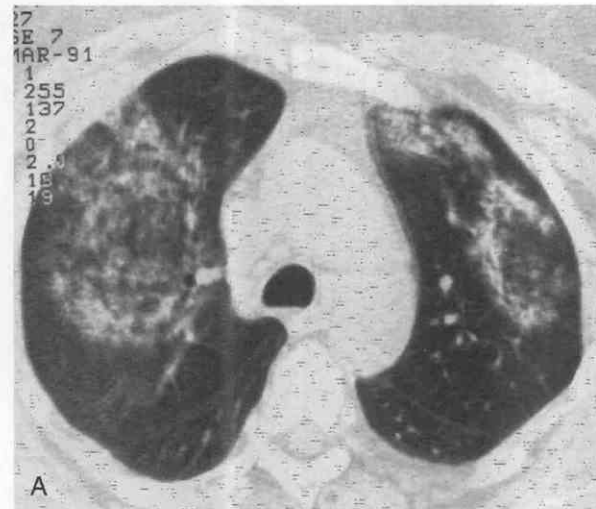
This patient presented with hemoptysis caused by Wegener's vasculitis affecting primarily the capillaries of the lung. A and B, On CT scans, patchy air space filling is seen as a result of pulmonary hemorrhage. C, A few weeks later, a CT scan shows nearly complete clearing of the air space disease.
